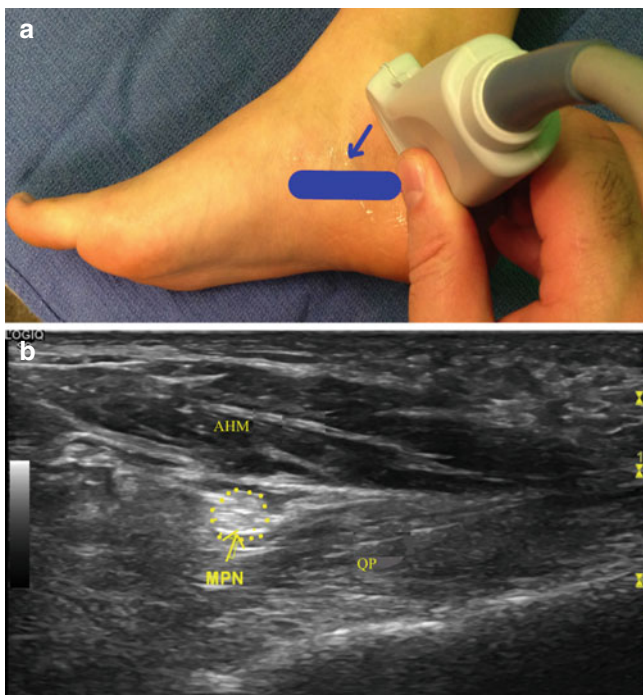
In-plane ultrasound evaluation of the medial plantar nerve. (a) Surface landmarks; (b) ultrasound evaluation of the medial arch of the foot; *MPN* medial plantar nerve, *AHM* abductor hallucis muscle, *QP* quadratus plantae (Image courtesy of Michael Brown, MD)
